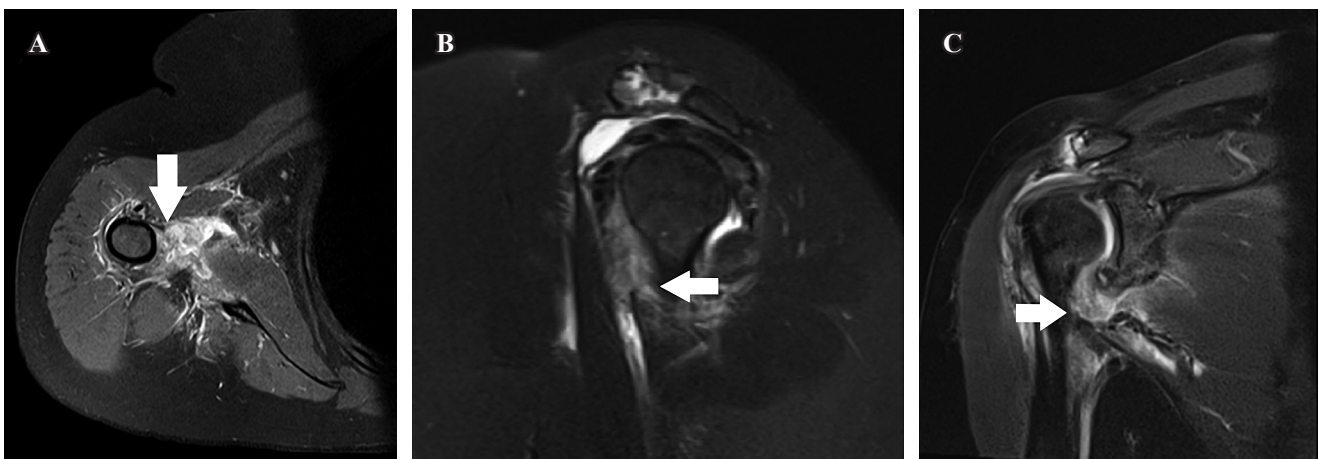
Magnetic resonance imaging in the axial section in A) the proton density fat saturated (DP FAT SAT) sequence and B) in the sagittal section and C) coronal section in the T2 FAT SAT sequence detecting insertional rupture of the latissimus dorsi and teres major muscles (white arrow).
